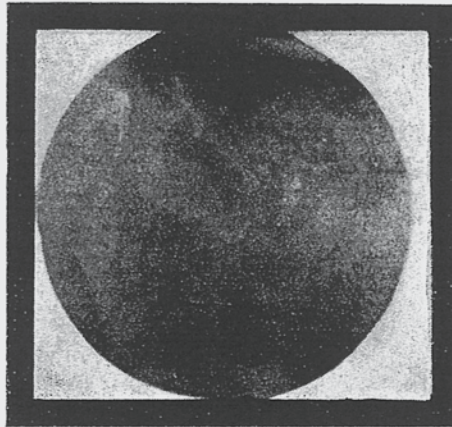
Même malade. Radiographie de contact à cône rétréci centrée sur les calcifications punctiformes.
